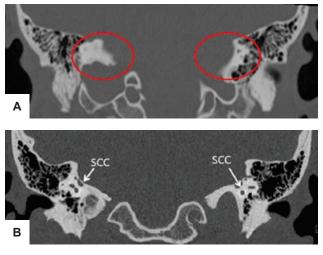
(A) CT temporal bones coronal view showing bilateral absence of all semi-circular canals (SCC); (B) The temporal bones of a normal patient for comparison.
